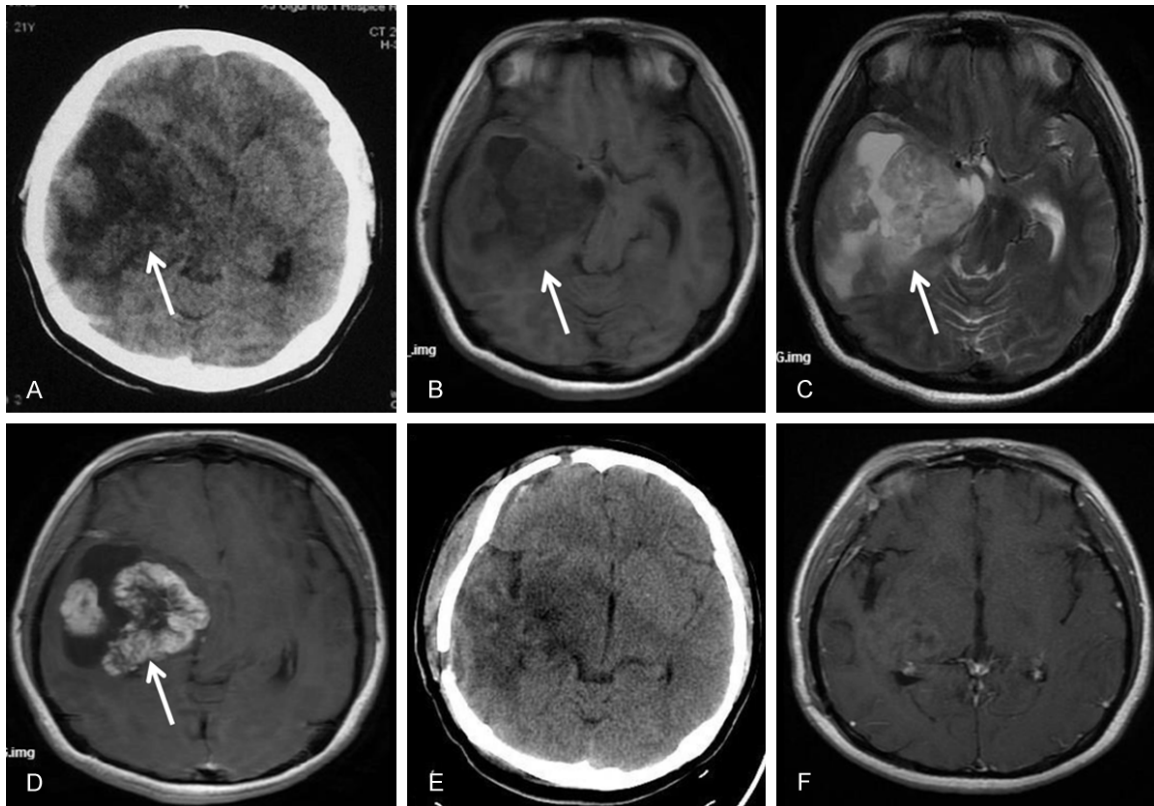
Case 1: CT and MRI images of patients with atypical teratoma/rhabdoid tumor before and after operation. A. Preoperative CT showed large patch of mixed density on the right temporal lobe (arrow). B. Preoperative MRI T1WI showed huge mass of mixed signal on the right temporal lobe with cystic long T1 signal (arrow). C. Preoperative MRI T2WI showed huge mass of mixed signal on right temporal lobe with cystic long T2 signal (arrow). D. Preoperative enhanced MRI showed significant lace-like enhancement, with no enhancement of the cyst (arrow). E. Postoperative CT showed slightly low density on the right temporal occipital lobe. F. Postoperative enhanced MRI (2-month) showed postoperative changes, with mild flocculent enhancement in the operation area.
